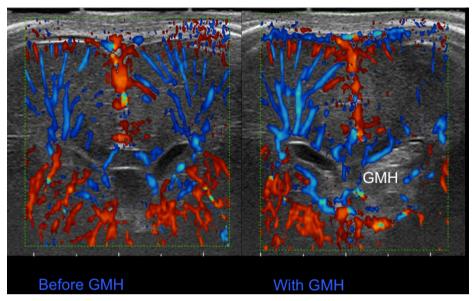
Left image: Cranial ultrasound image including colour Doppler. Coronal view at level of Monro, with 13 Mhz probe showing both hemispheres with microvessels in the periventricular white matter. Image before germinal matrix haemorrhage, symmetrical perfusion
